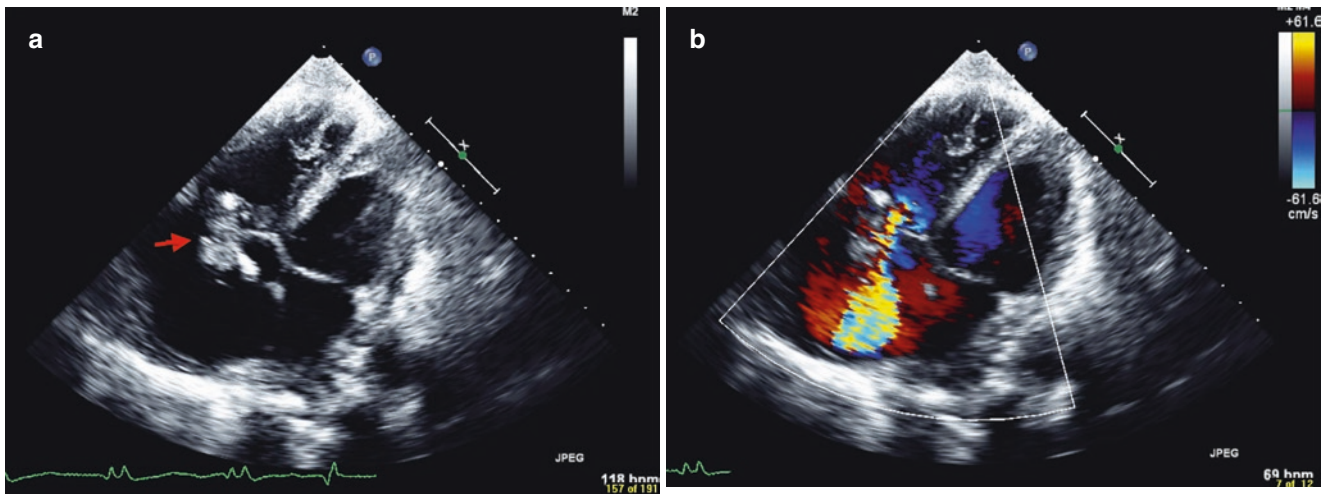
TTE of large tricuspid valve vegetation. (a) Apical view. (b) Apical view with Color Doppler showing Tricuspid regurgitation
